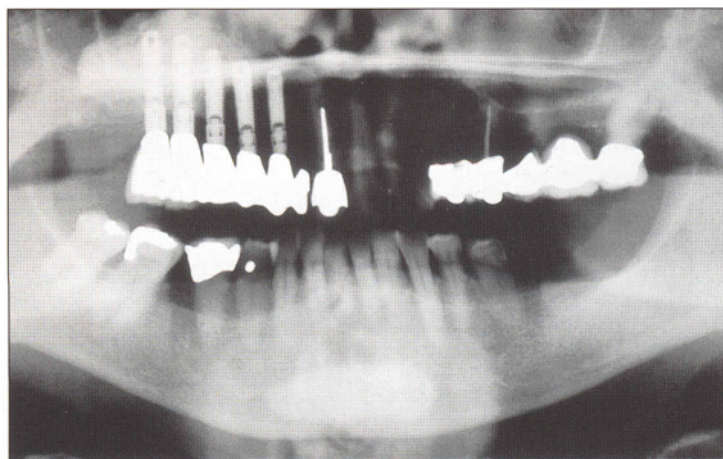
Panoramic radiograph of the restored maxillary implants.
